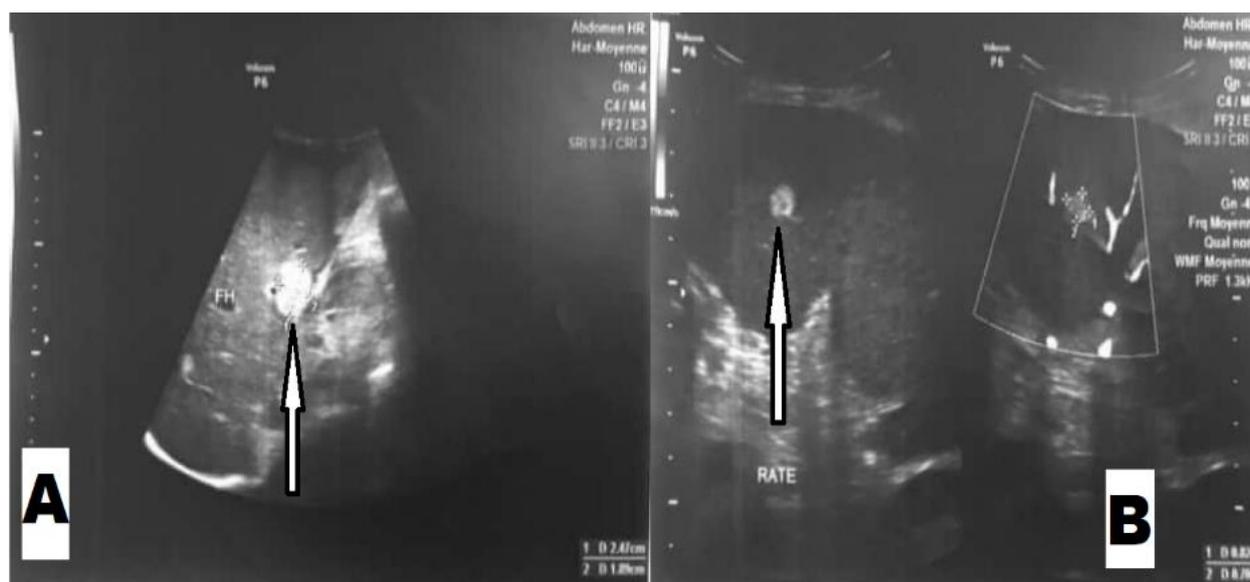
Abdominal ultrasound showing cardiac liver with signs of portal hypertension, two nodules in hepatic segments IV and VI measuring 8 and 29 mm respectively (A), a medio-splenic nodule measuring 8×7mm(B)
